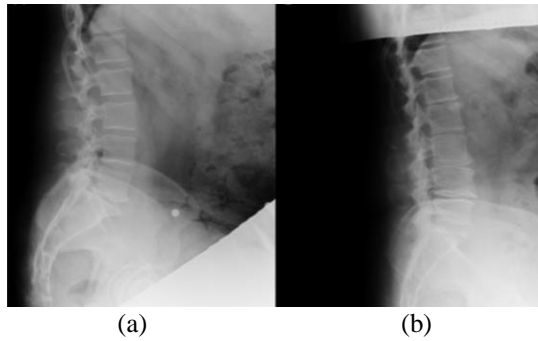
Lumbar radiographs (a) without disease, (b) with disease.
